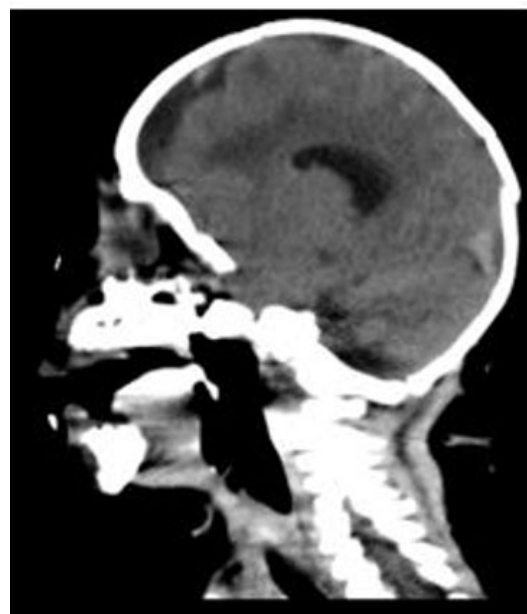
Sagittal CT image showing absent corpus callosum.
